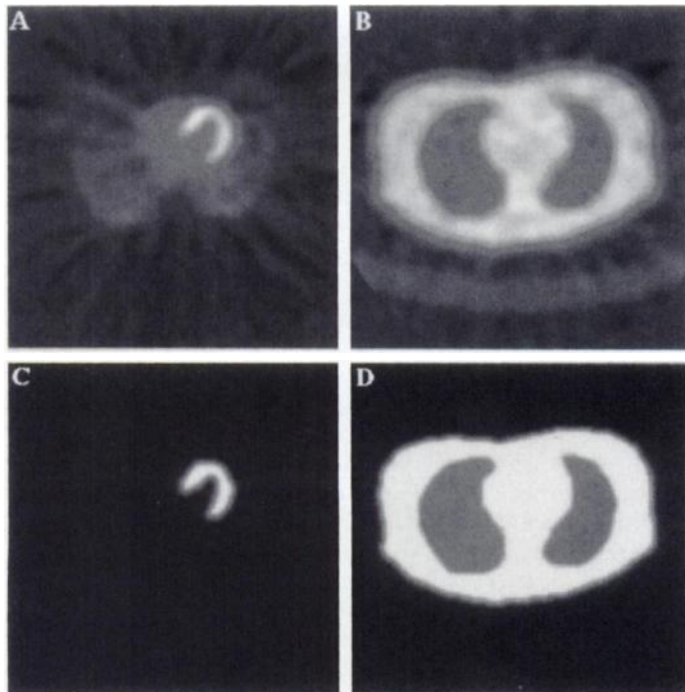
(A) Filtered backprojection reconstruction of PET transaxial slice. (B) Filtered backprojection reconstruction of corresponding PET transmission slice. (C) Resampled and segmented PET data corresponding to A. (D) Resampled and segmented PET data corresponding to B. Images C and D were used as models to generate SPECT projection data.
